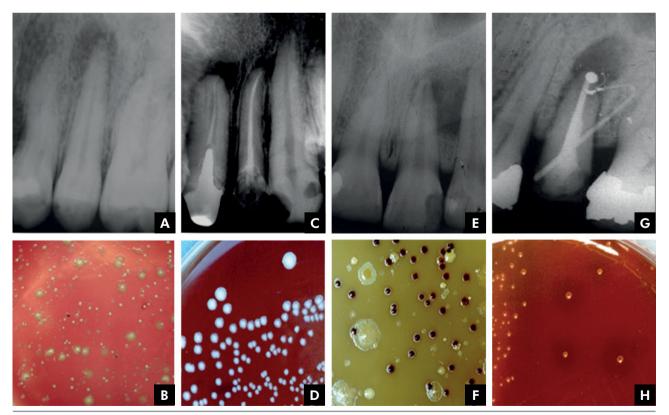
Radiographic aspects and microbial culture plates of different types of endodontic infections. A-B - Primary infection; C-D - Secondary infection; E-F- Periapical abscess; and G-H- Apical Biofilm
